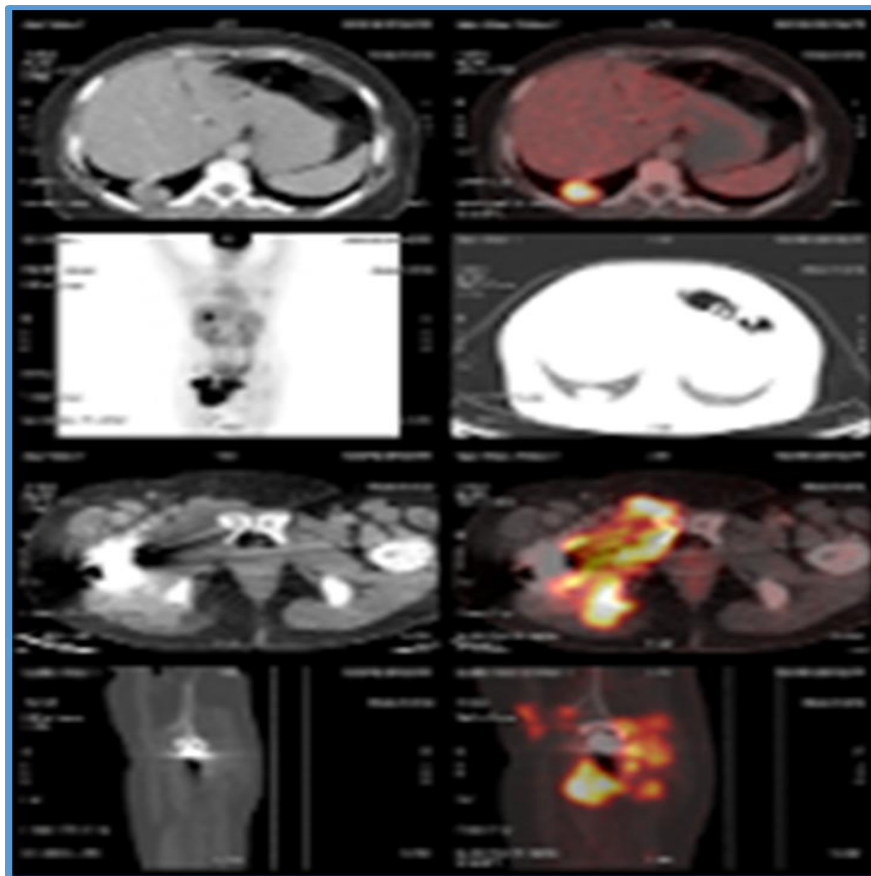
PET-CT of right thigh showing increased FDG uptake seen in the centrally hypodense lesion involving the right oblique muscles in the pelvic region.
